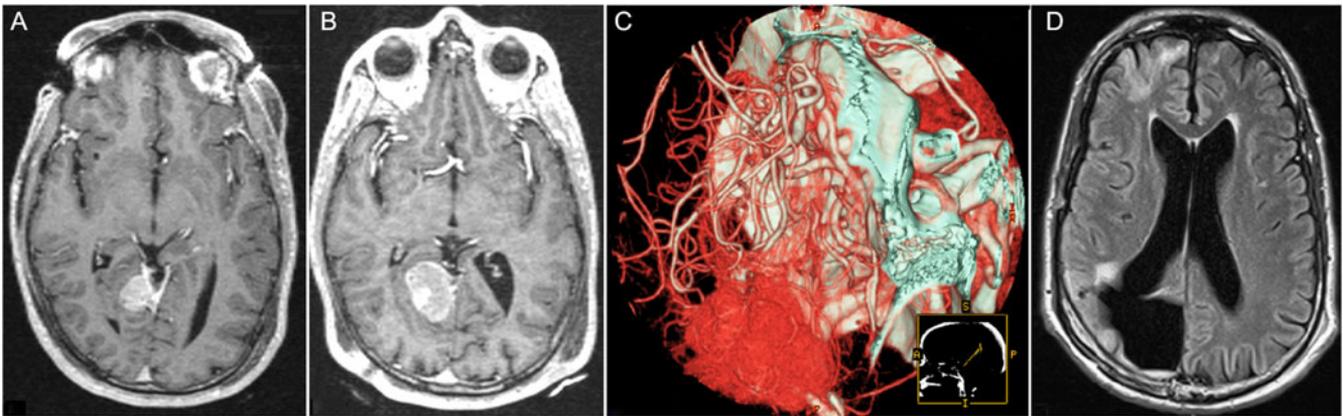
Sample Patient, Hemangiopericytoma. (A) Axial T1WI with gadolinium taken on the day of stereotactic radiosurgery (SRS) for a right tentorial hemangiopericytoma, s/p 1 surgical resection, 4/2002. (B) Axial T1WI with gadolinium taken on the day of repeat SRS for the same lesion, 12/2005. (C) CT-angi reconstruction pre-embolization and second surgical resection of the same lesion due to progression, 6/2009. (D) Follow-up images, 20 months after the second surgical resection, in TIWI-FLARE, showing final local control, 02/2011. Adapted from Cohen-Inbar et al.¹⁰
